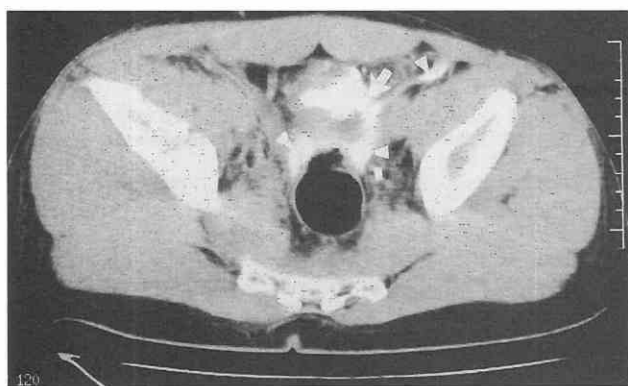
Intraperitoneal bladder rupture. CT cystogram shows left-sided bladder wall rupture (arrow) and free intraperitoneal contrast agent (arrowheads). Note the presence of a right iliac blade fracture.
